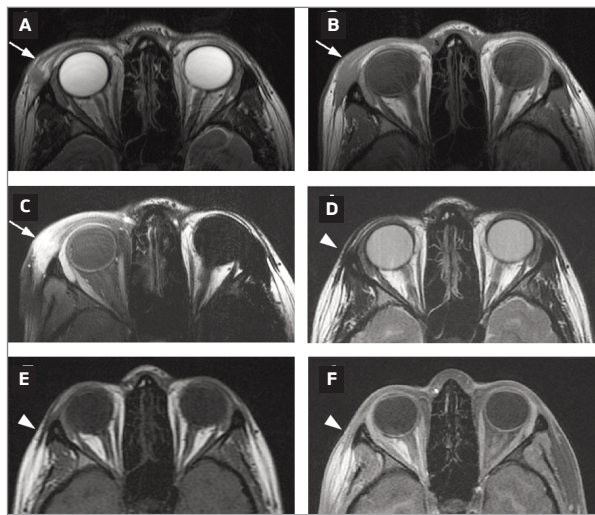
Diagnostic MRI with axial T2WI (A), axial T1WI (B), and axial contrast enhanced T1WI (C) shows a poorly defined mass in the external periorbital region, with heterogeneous T2 signal intensity and avid enhancement (arrows). Follow up MRI 1 year after treatment onset with axial T2WI (D), axial T1WI (E), and axial contrast enhanced T1WI (F) shows complete resolution of the mass (arrow heads).
